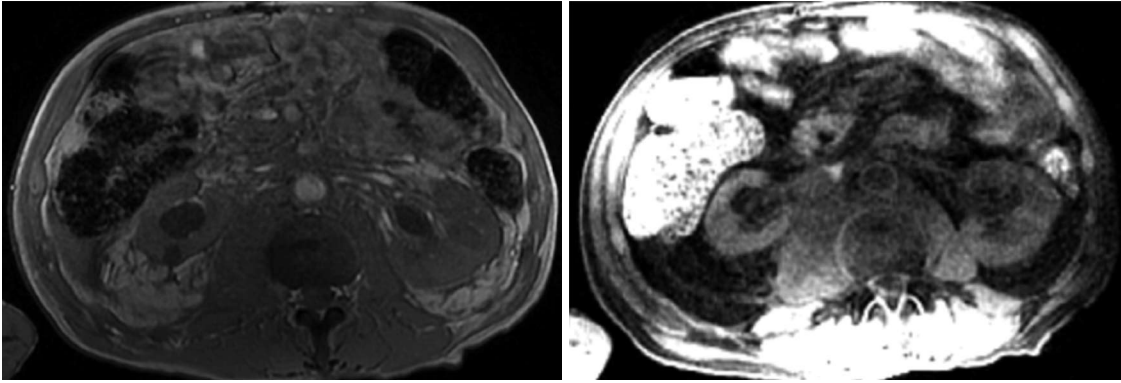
Magnetic resonance imaging of the abdomen revealing an ill-defined retroperitoneal infiltrate.
